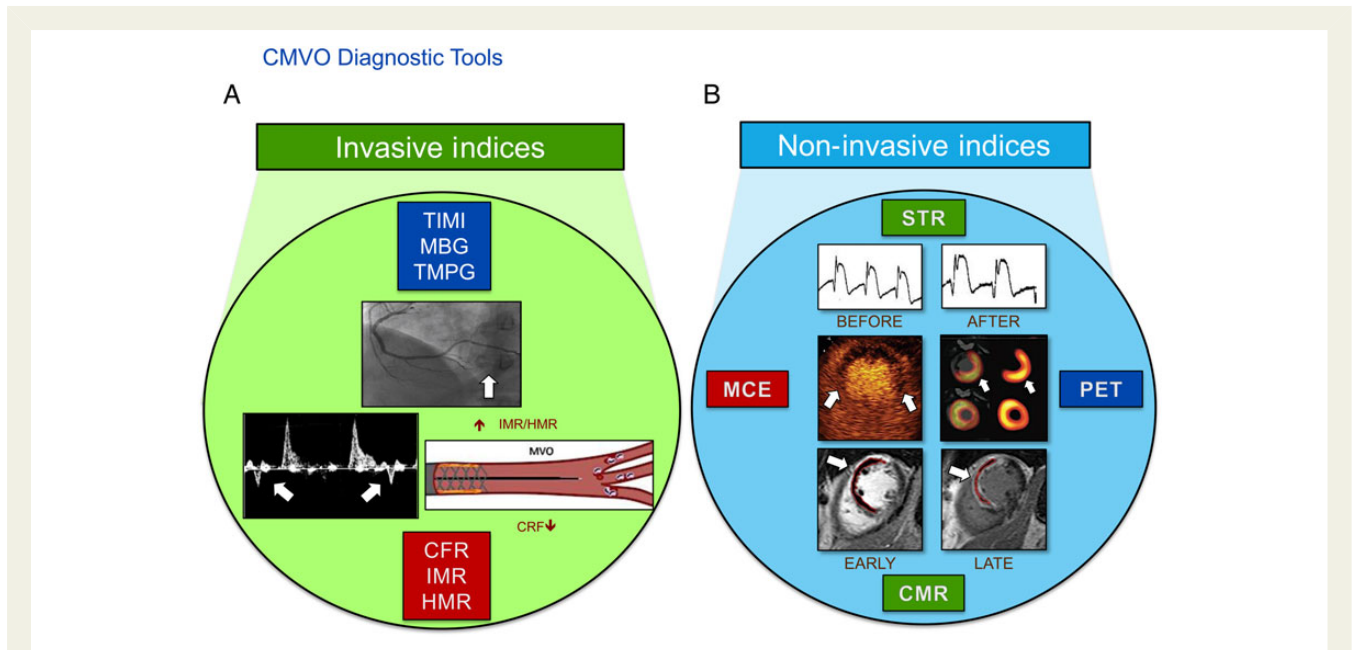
The diagnostic indices for coronary microvascular obstruction detection, classified as invasive (green circle) (A) or non-invasive tools (blue circle) (B). *Invasive indices*: The gold standard method for coronary microvascular dysfunction and obstruction assessment is the direct measurement of coronary flow reserve using intracoronary Doppler wire; the typical coronary microvascular dysfunction and obstruction pattern is characterized by systolic retrograde flow, diminished systolic anterograde flow, and rapid deceleration of diastolic flow. The figure at the bottom, left position, shows the systolic retrograde flow (white arrows) during intracoronary Doppler. The index of microvascular resistance provides a more reproducible assessment of microcirculation, independent of haemodynamic perturbations whereas hyperaemic microvascular resistance is associated with ventricular recovery and clinical outcome after ST-segment elevation myocardial infarction. The image at the bottom, right position, shows the typical pattern of coronary microvascular dysfunction and obstruction: reduced coronary flow reserve and increased index of microvascular resistance/hyperaemic microvascular resistance. Angiographic parameters of coronary microvascular dysfunction and obstruction are represented by thrombolysis in myocardial infarction flow score, myocardial blush grade, and thrombolysis in myocardial infarction myocardial perfusion grade. Of note, it is becoming common practice to define angiographic coronary microvascular dysfunction and obstruction as follows: thrombolysis in myocardial infarction flow grade <3 or 3 with an myocardial blush grade or thrombolysis in myocardial infarction myocardial perfusion grade 0–1. The image at the top shows a case of angiographic coronary microvascular dysfunction and obstruction (white arrow) in the posterior descending artery of the right coronary artery. *Non-invasive indices* (light blue circle): ST-segment resolution represents an useful tool of coronary microvascular dysfunction and obstruction, also considering its prognostic value (see the image at the top, left position, for the ST before opening infarct-related artery; see the image at the top, right position, for the ST after opening infarct-related artery during coronary microvascular dysfunction and obstruction). Myocardial contrast echocardiography can be employed for coronary microvascular dysfunction and obstruction diagnosis. The typical pattern is represented by lack of intra-myocardial contrast opacification (indicated by white arrows, in the image in the centre, left position). Cardiac magnetic resonance allows multislice imaging with high tissue contrast and high spatial resolution, enabling accurate quantification, and localization of coronary microvascular dysfunction and obstruction and infarct size relative to the entire left ventricle; typical signs of coronary microvascular dysfunction and obstruction are represented by lack of gadolinium enhancement during first pass (indicated by white arrow, in the image at the bottom, on the left position) and lack of gadolinium enhancement within a necrotic region (late gadolinium hyper-enhancement) (indicated by white arrow, in the image at the bottom, on the right position). Finally, the hybrid positron emission tomography/cardiac computed tomography allows to monitor inflammatory reactions after reperfusion (indicated by white arrows, within the image in the centre, on the right position).
